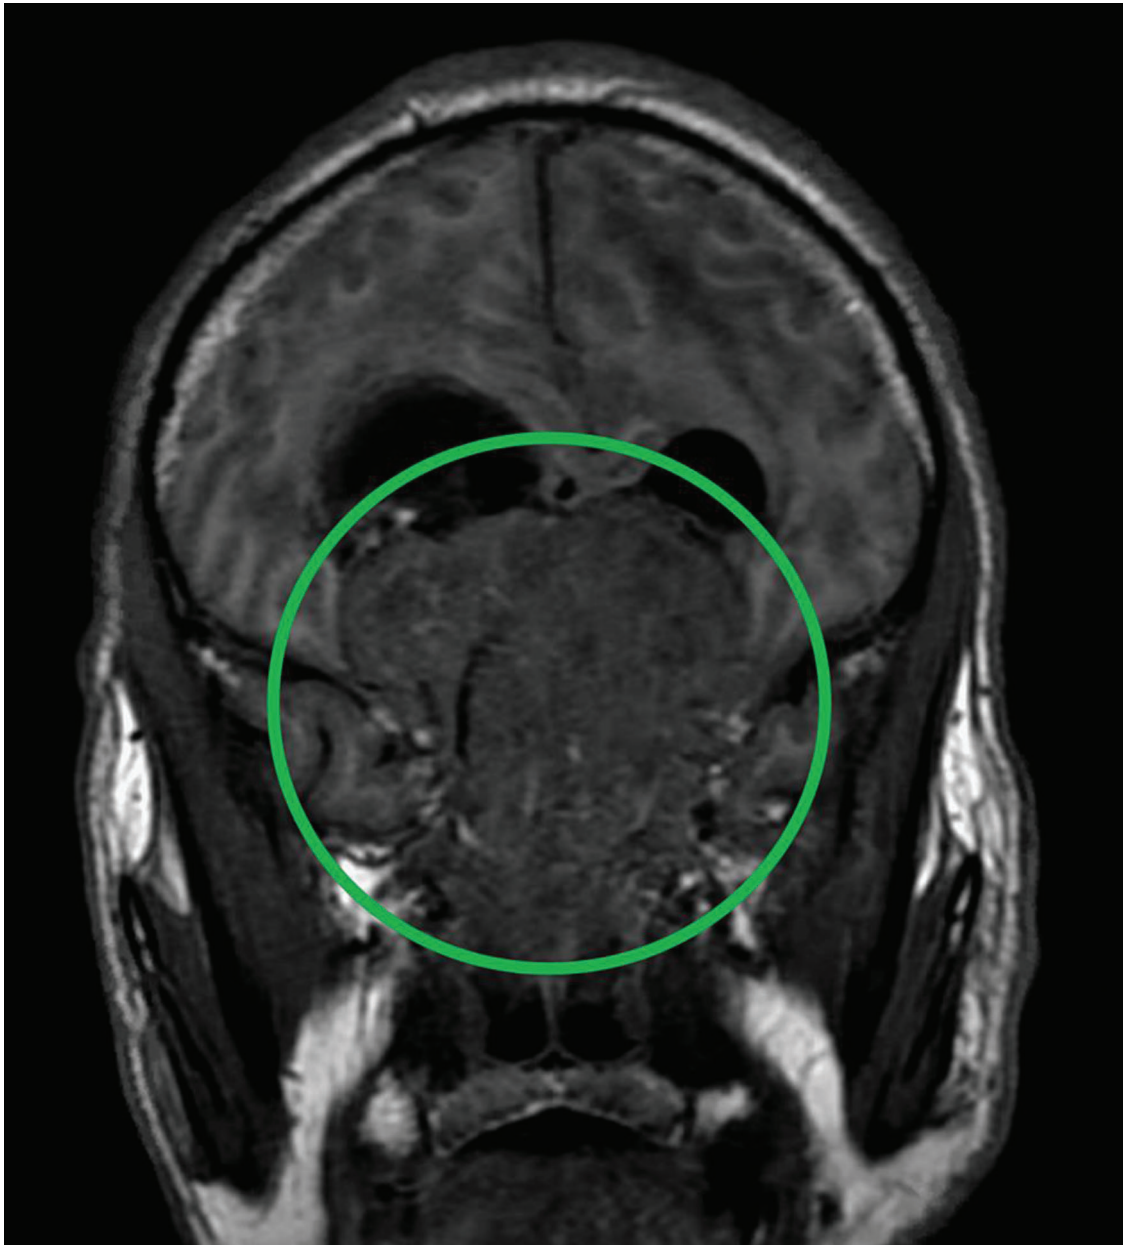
Coronal view T1 magnetic resonance imaging with contrast showing a large mass aiding in the suspicion of ENB.
